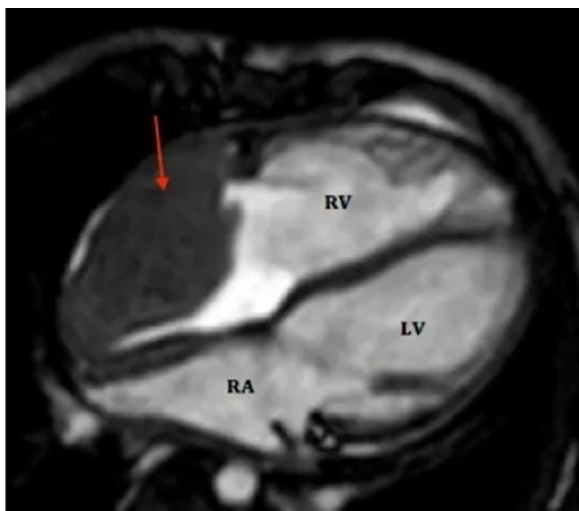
Cardiac MRI scan, four-chamber view, demonstrating giant mass into the right atrium (arrow), left atrium (LA), right ventricle (RV), left ventricle (LV).
